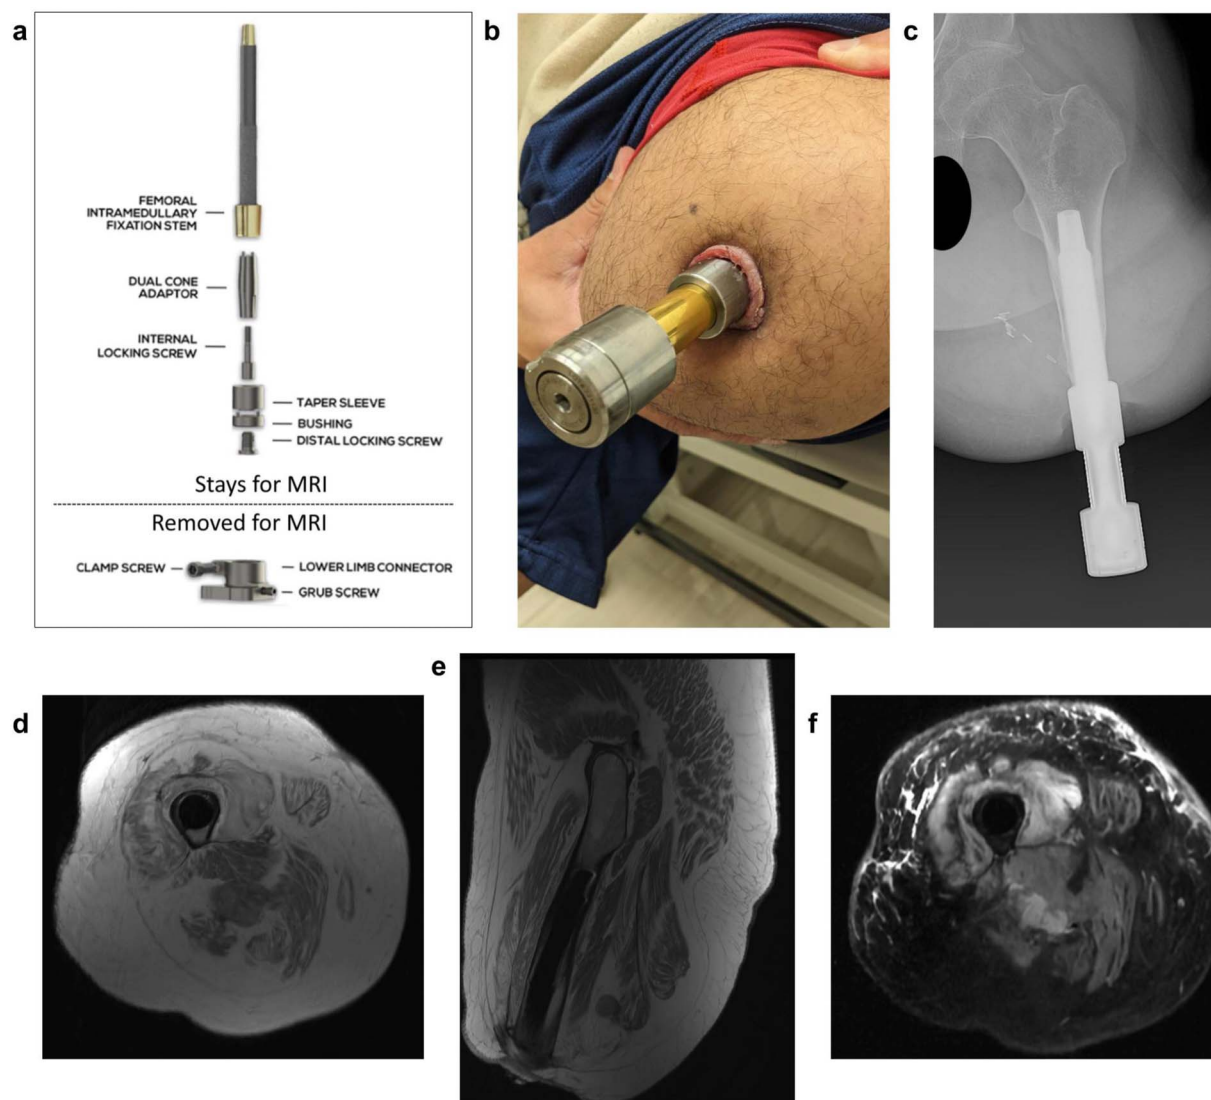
Osseointegration prosthetic limb (OPL) evaluated in this study. A, Exploded view with the components arranged at approximately the proximal-distal levels in which they would be once assembled and implanted in a patient who had undergone a femoral amputation. The figure identifies the upper components that remain connected to the implant (which is implanted into the patient) for the MRI, whereas the lower components are removed with the prosthetic leg as the patient is accustomed to doing for the MRI. Figure used with permission, modified for clarity, from Osseointegration Amputation Reconstruction, Reif TJ, Jacobs D, Fragomen AT, et al. *Curr Phys Med Rehabil Rep* 2022;10:61–70. B, Photograph showing a patient with transfemoral osseointegration, with the osseointegrated implant and attachment hardware on, but the prosthetic leg removed. Radiograph of the OPL implant in a patient who had undergone a femoral amputation. C, Anterior-posterior radiograph of the left femur with the osseointegration implant in the patient's femur and attachment hardware on the distal aspect of the implant, but the prosthetic leg removed. D, 1.5-Tesla axial T1 MRI proton density pulse sequence of the same patient; note the titanium implant (occupying the entirety of the femoral canal) is completely dark and the resolution of the local anatomy is good quality. E, Sagittal T1 MRI proton density pulse sequence of this patient shows again the dark outline of the implant within the femur and good resolution of adjacent anatomy. F, Axial T2 inversion recovery sequence again shows the implant within the canal to be dark and the local anatomy to be of good resolution. This patient's MRI was obtained to evaluate for potential osteomyelitis or other local infection, which was not identified. Intramuscular edema is noted, which is consistent with muscle atrophy in this specific patient who had a prolonged period of immobility.
